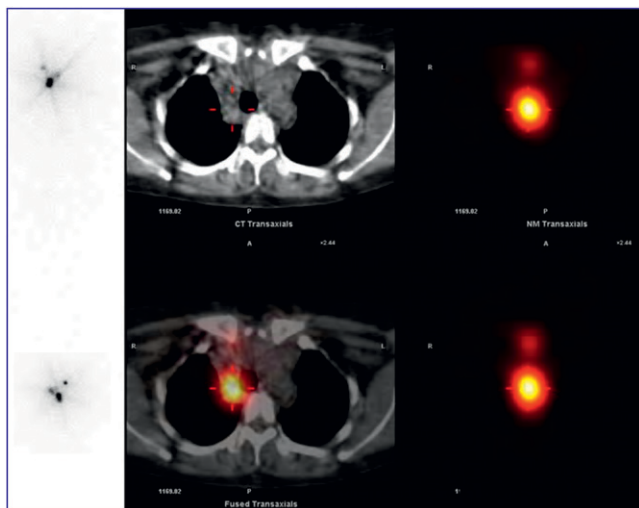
59-year-old woman referred for high-dose radioiodine therapy after thyroidectomy for papillary thyroid cancer. Left: Planar whole-body scintigraphy 8 d after administration of 120 mCi ^{131}I showed multiple foci of increased tracer uptake in neck. Right: SPECT/CT of neck and chest localized uptake to right lower paratracheal lymph nodes, changing stage from M0 to M1.
